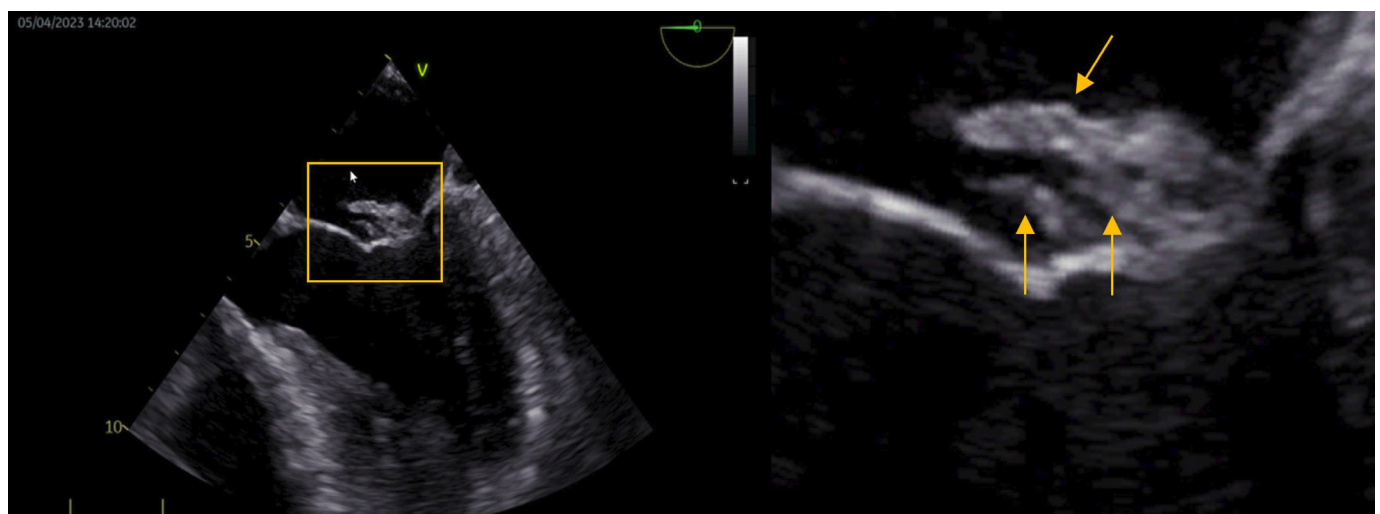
Transoesophageal echocardiography multiple vegetations on the mitral valve that increase the embolic risk; right panel: zoomed-in image with three detailed vegetations (arrows).
